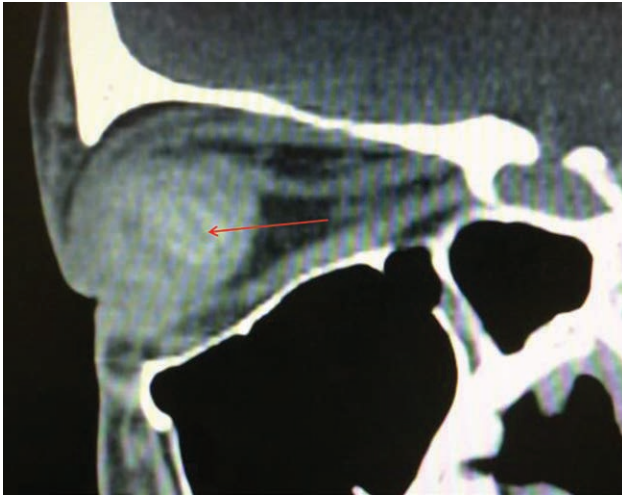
Case 4. Postoperative CT examination showed the spherical costal cartilage implant in her orbit (red arrow).
